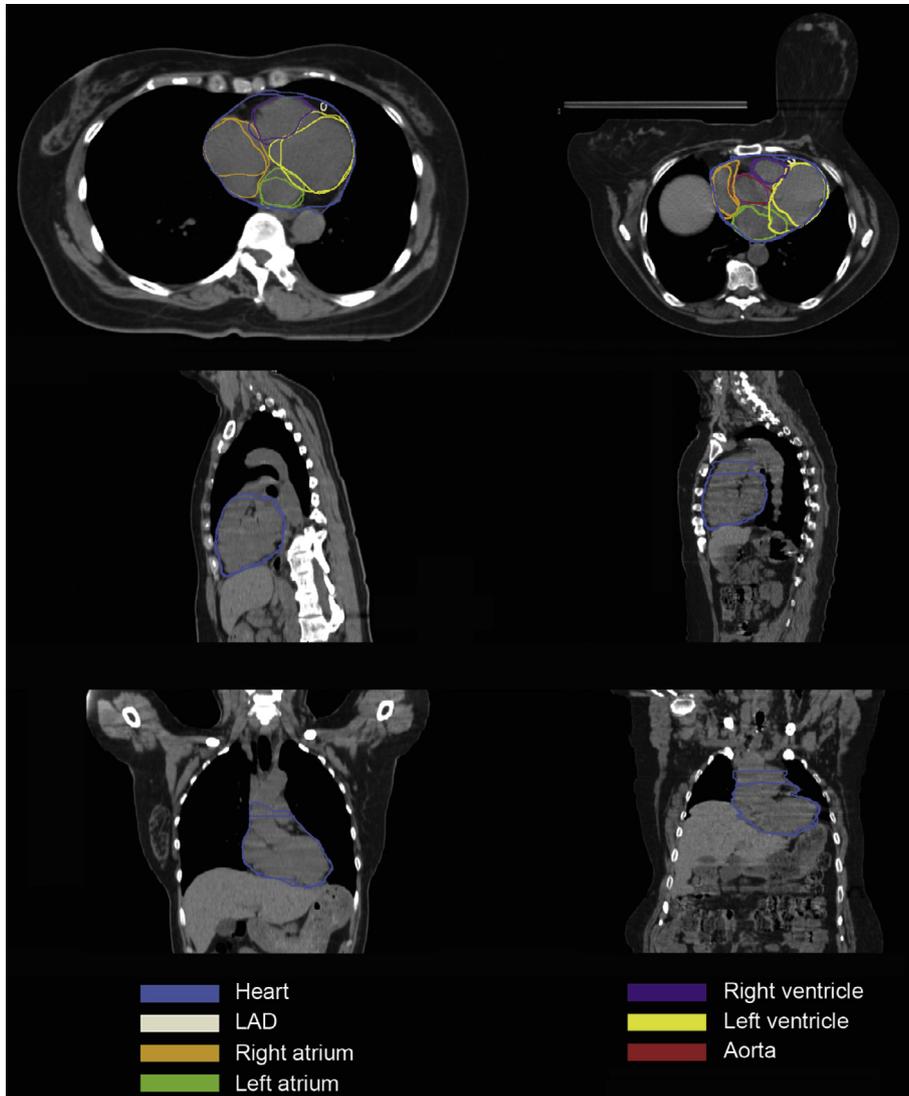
CT images showing the overlay of manual and atlas based auto-segmented contours. Left side shows a patient imaged in supine position with an average Dice-similarity coefficient for the whole heart (0.93). Right side shows the patient with the lowest whole heart Dice-similarity coefficient (0.86). The right patient was imaged in prone position, which was rare in the atlas. LAD denotes the left anterior descending artery.
